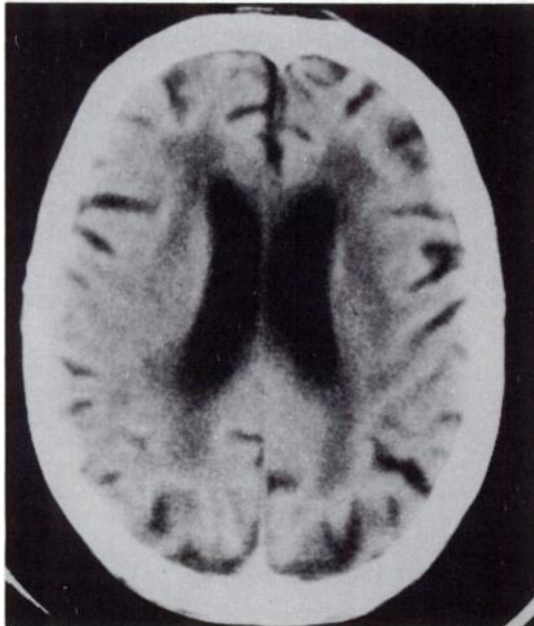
CT scan from case 1 shows confluent subfrontal and parietal lucencies and atrophy.
